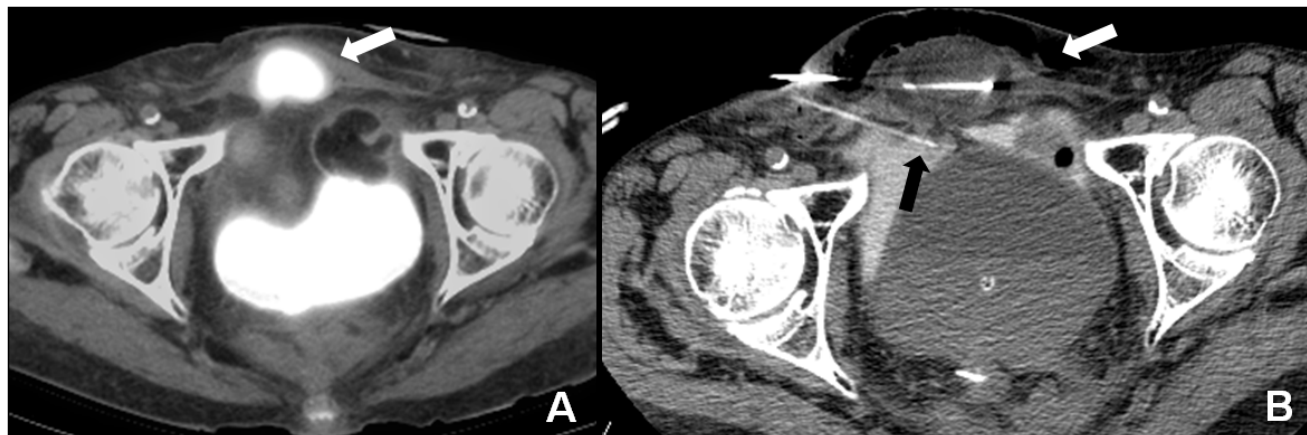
A 75 year old female with endometrial cancer status post radiation presented with complaints of a painful nodule on her lower abdominal wall. PET-CT revealed a highly FDG-avid 5x2.7cm anterior pelvic wall mass (left, white arrow). Two months later, the patient presented for cryoablation of this superficial metastasis. Intraprocedurally (right), hydrodissection was used to displace the bladder and colon inferiorly by instilling warmed saline mixed with contrast by means of a percutaneously placed catheter (black arrow). To protect the overlying skin, air insufflation (white arrow) was used to raise the skin and subcutaneous tissues superiorly. In clinical post-ablation follow-up the patient was noted to no longer have pain at this site.
